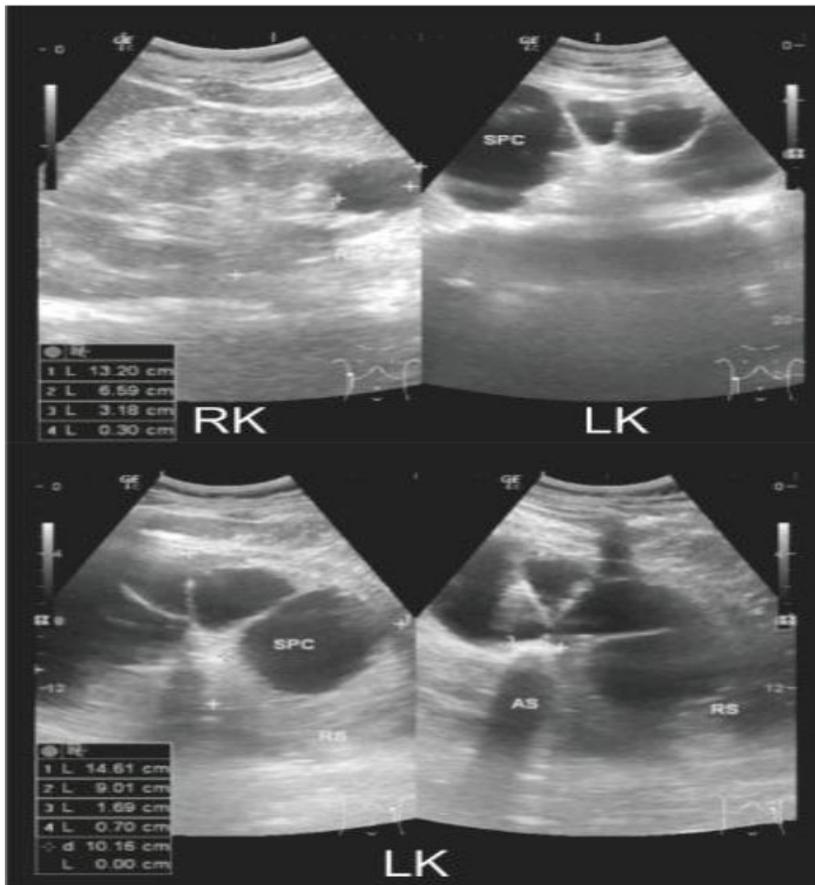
The ultrasound reveals severe left hydronephrosis with thin kidney parenchyma, indicating a poor-functioning left kidney and a hyperechoic lesion with a posterior acoustic shadow suggesting a stone.
